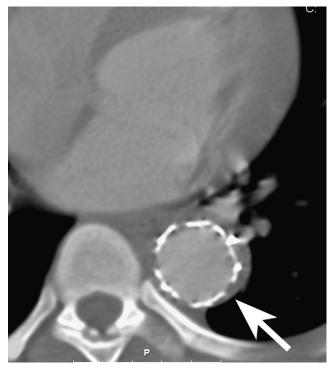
Contrast enhanced CT scan 18 months following stent grafting. There is continued patency of the stent graft and no visible ulceration or aneurysm formation outside the graft (white arrow).
